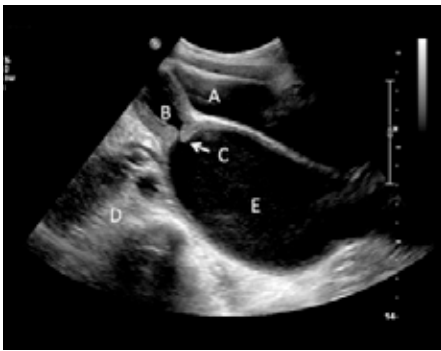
Longitudinal section transabdominal ultrasound image of the pelvis demonstrating haematocolpometra. A = bladder containing urine; B = peri-pubertal uterus abnormally distended with fluid (menses); C = cervical canal; D = rectum; E = vagina markedly distended with menses.
